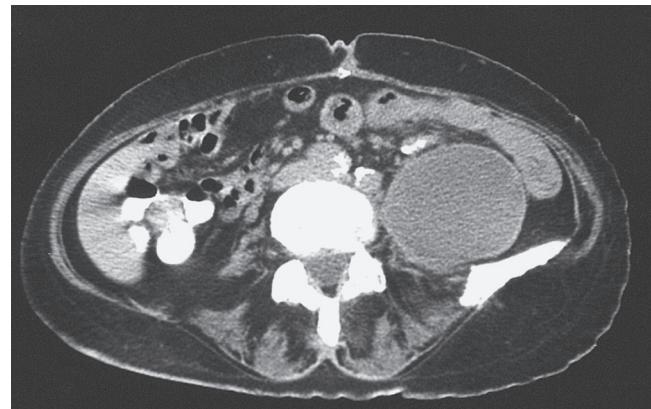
Computed tomography in a 70-year-old woman reveals a large left retroperitoneal lymphocele 9 months after repair of a thoracoabdominal aortic aneurysm.
